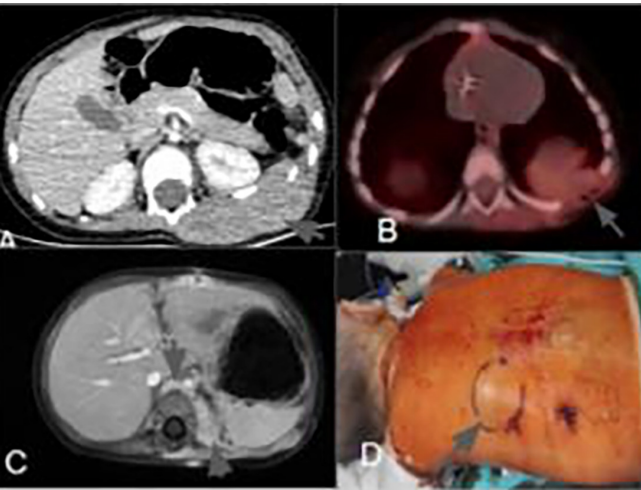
A. CT image of the retroperitoneal mass near the spleen and kidney. B. PET-CT image pre-resection metabolic activity. C. MRI of recurrent tumor at L1-L2 levels. D. Postoperative view; showing the recurrent tumor site.
